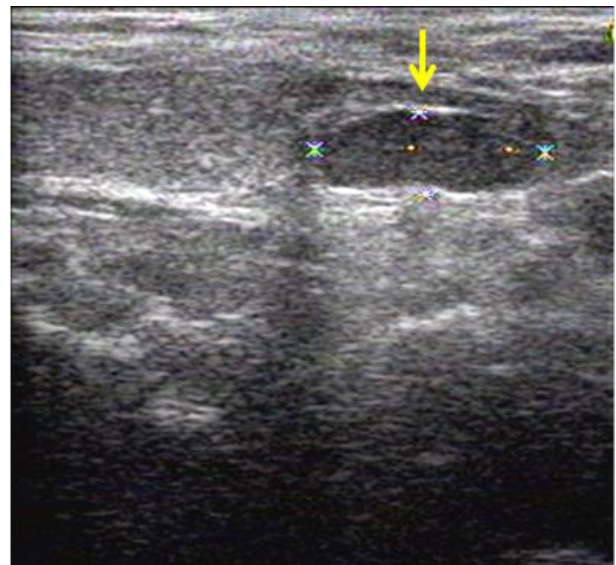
Anterior cervical ultrasound: left inferior parathyroid nodule (yellow arrow)
